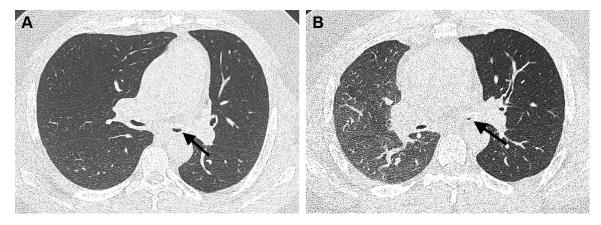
A-B, Paired inspiratory and expiratory HR CT images in a 34-y-old woman with history of relapsing polychondritis. A, Inspiratory HR CT scan shows thickened (partially calcified) cartilaginous bronchial rings and small caliber but patent left main bronchus (arrow) with uniform lung attenuation. B, Expiratory HR CT scan shows normal increased density in the right lung but complete collapse of the left main bronchus (arrow) with associated air trapping and paradoxical increased volume in the left lung. See Figure 24 legend for expansion of abbreviation.
